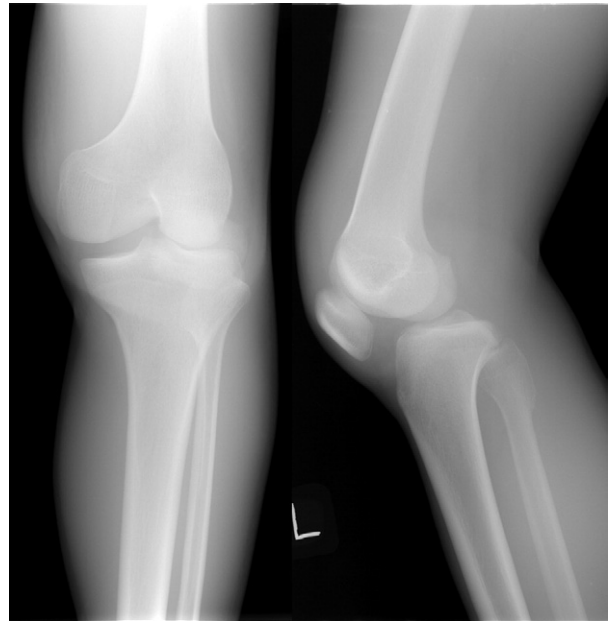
Anteroposterior and lateral radiographic views in a 29-year-old man (case 10) who presented with a reduced knee. Clinical and radiologic examination confirmed rupture of the ACL, PCL, and MCL.
